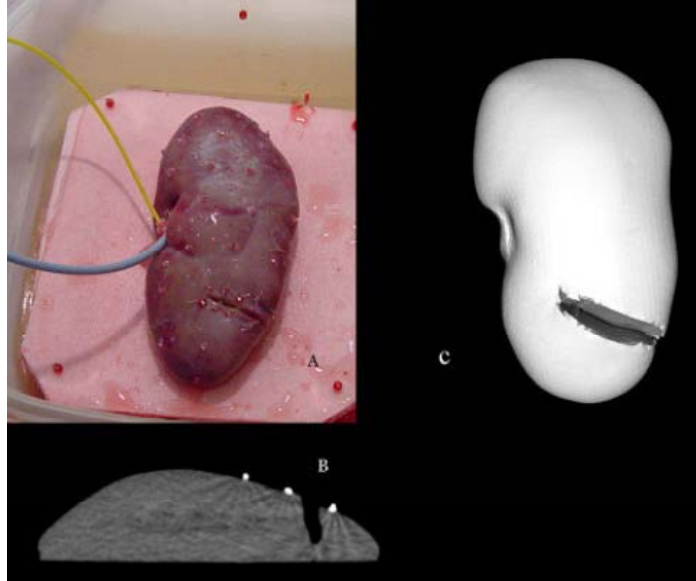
Incised kidney. A) shows the kidney and the fiducial positions (red beads). B) shows a CT scan to show the depth of the incision while c) is a rendering of the full CT.
